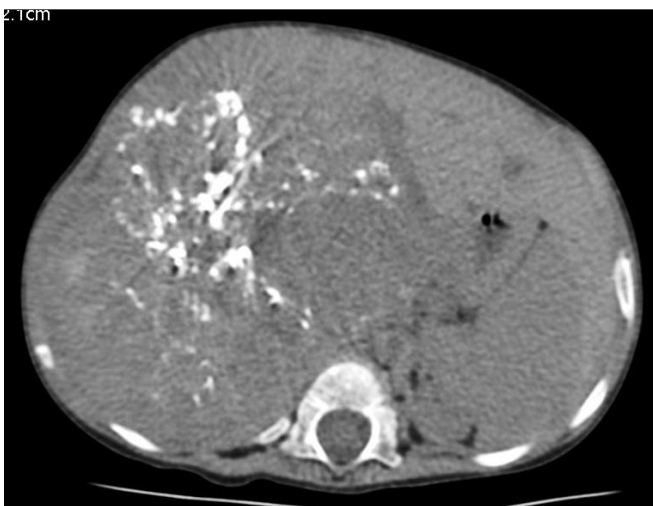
Axial Plain CT abdomen shows grossly enlarged liver with a 101 (T) x 102 (AP) x 91 (CC) mm sized large lobulated soft tissue density lesion with coarse calcifications & hypo-dense area within in right lobe of liver. The lesion abuts stomach and right kidney with preserved fat planes
